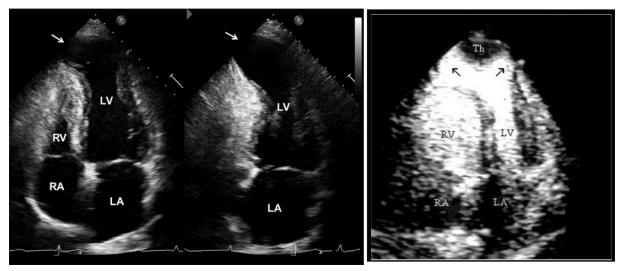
Left ventricular apical aneurysm (arrows) in patients with HF. (Left) Apical four- and two-chamber views of a patient with ChHD in stage B2 with a large left ventricular apical aneurysm (white arrows); the right ventricle (RV) has a normal size. (Right) Contrast echocardiography for left ventricular opacification in a different patient with ChHD and biventricular damage shows a large apical aneurysm (black arrows) with a thrombus (Th). Arrows show areas of dyskinesis. Contrast infusion defines the extension of the aneurysm and size of the thrombus. The right ventricle is more dilated than the left ventricle (LV). LA, Left atrium; RA, right atrium.
